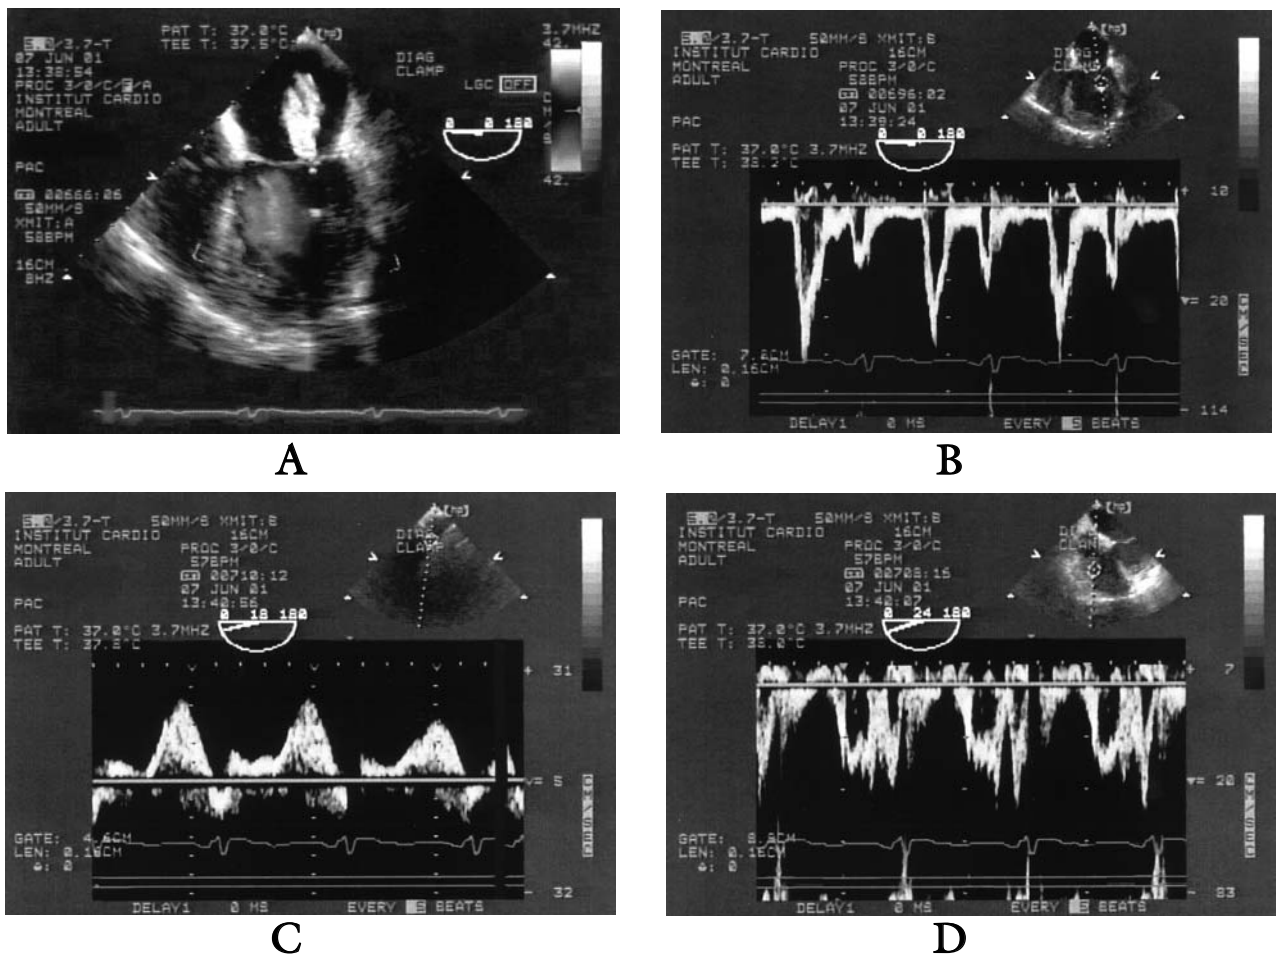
Transesophageal echocardiography findings after stabilization and clamping of the diagonal coronary artery. Hepatic flow values were missing. Findings were compatible with a restrictive left ventricular diastolic pattern and a relaxation anomaly of the right ventricular diastolic function. A) moderate mitral regurgitation; B) mitral flow E and A wave velocities were 81.6 and 30.5 $\text{cm}\cdot\text{sec}^{-1}$ respectively (E/A ratio = 2.68). The E wave deceleration time was 190 msec; C) pulmonary venous flow systolic and diastolic wave velocities were 8.99 and 23.6 $\text{cm}\cdot\text{sec}^{-1}$ respectively; D) tricuspid flow E and A wave velocities were 31.7 and 40.8 $\text{cm}\cdot\text{sec}^{-1}$ respectively (E/A ratio = 0.78).
